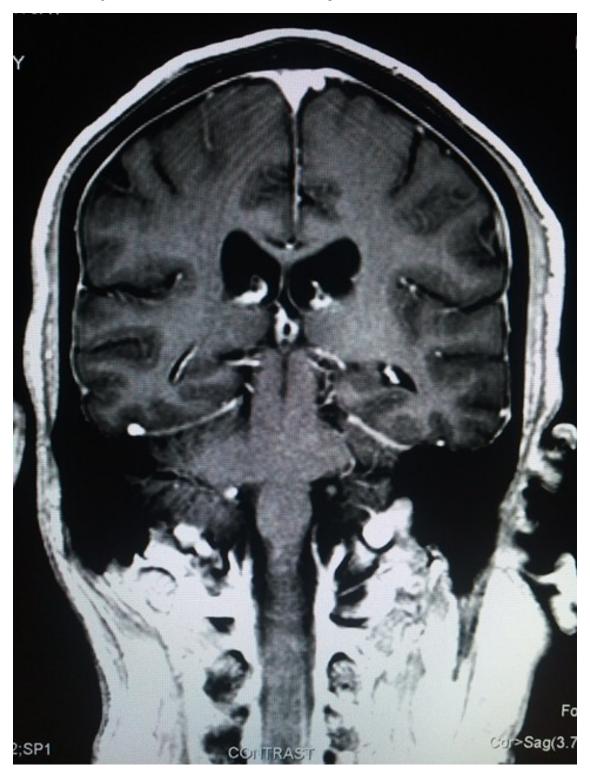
MRI of brain revealed features of pachymeningitis
